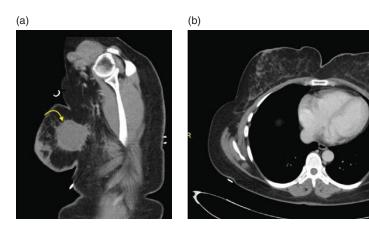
(a, b) Contrast-enhanced CT-scan CHEST soft tissue window shows a well-circumscribed round-shaped hypodense collection with thickened and irregular enhancing outer wall in a background of post-surgical changes.
